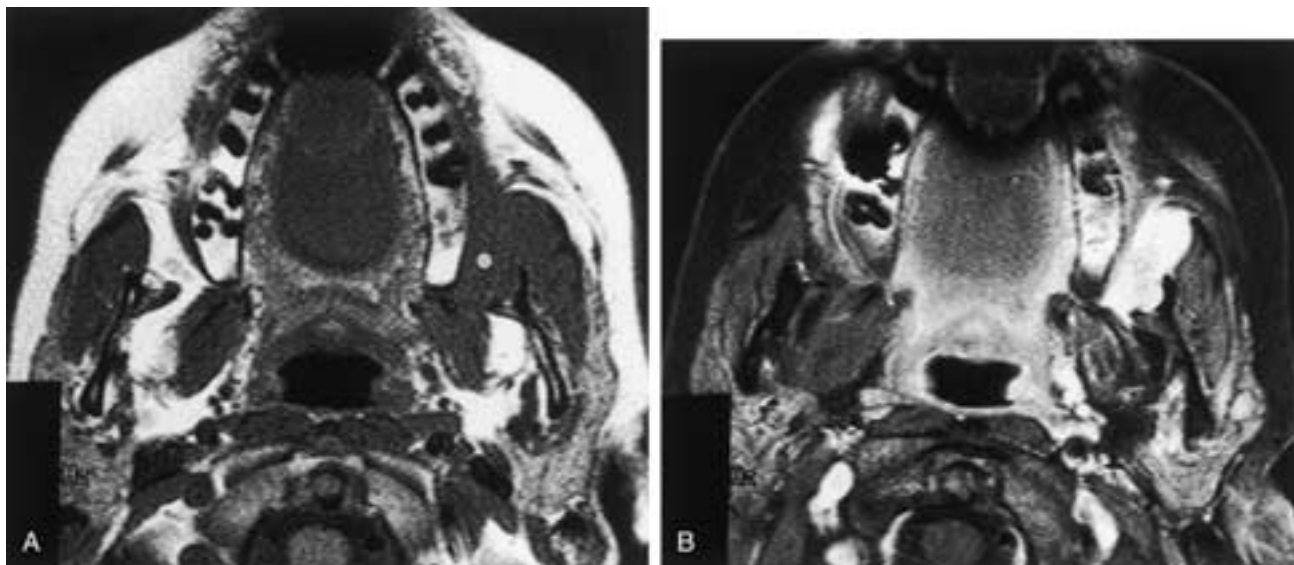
Left retromolar trigone squamous cell carcinoma. A, Axial T1-weighted MR images reveals obliteration of the left buccal space fat between the maxilla and mandible by a soft-tissue mass (*dot*). The signal intensity is such that separation from adjacent muscle tissue and definition of tumor margins are not possible. B, Contrast-enhanced T1-weighted axial MR image obtained with the fat suppression technique optimally demonstrates the presence and extent of the tumor margins. Compare this image with the postcontrast images in [Figure 27-102](#) that were not obtained with the fat suppression technique. (Courtesy of Dr. Deborah Reede.)
